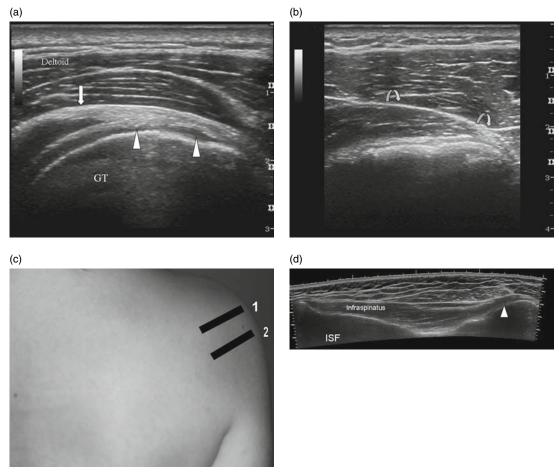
Longitudinal ultrasound of (a) infraspinatus tendon (arrowheads) and musculotendinous junction (arrow) and (b) teres minor (curved arrows). Note the short hyperechoic tendon of the teres minor, which can be used to differentiate from the infraspinatus. (c) Transducer positions. (d) Extended field of view ultrasound of the infraspinatus. 1, infraspinatus; 2, teres minor; GT, greater tuberosity; ISF, infraspinous fossa scapula.
